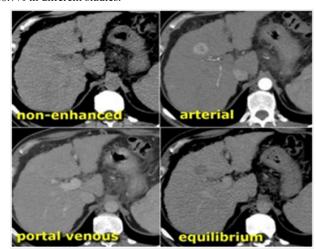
CT imaging of hepatocellular carcinoma.
